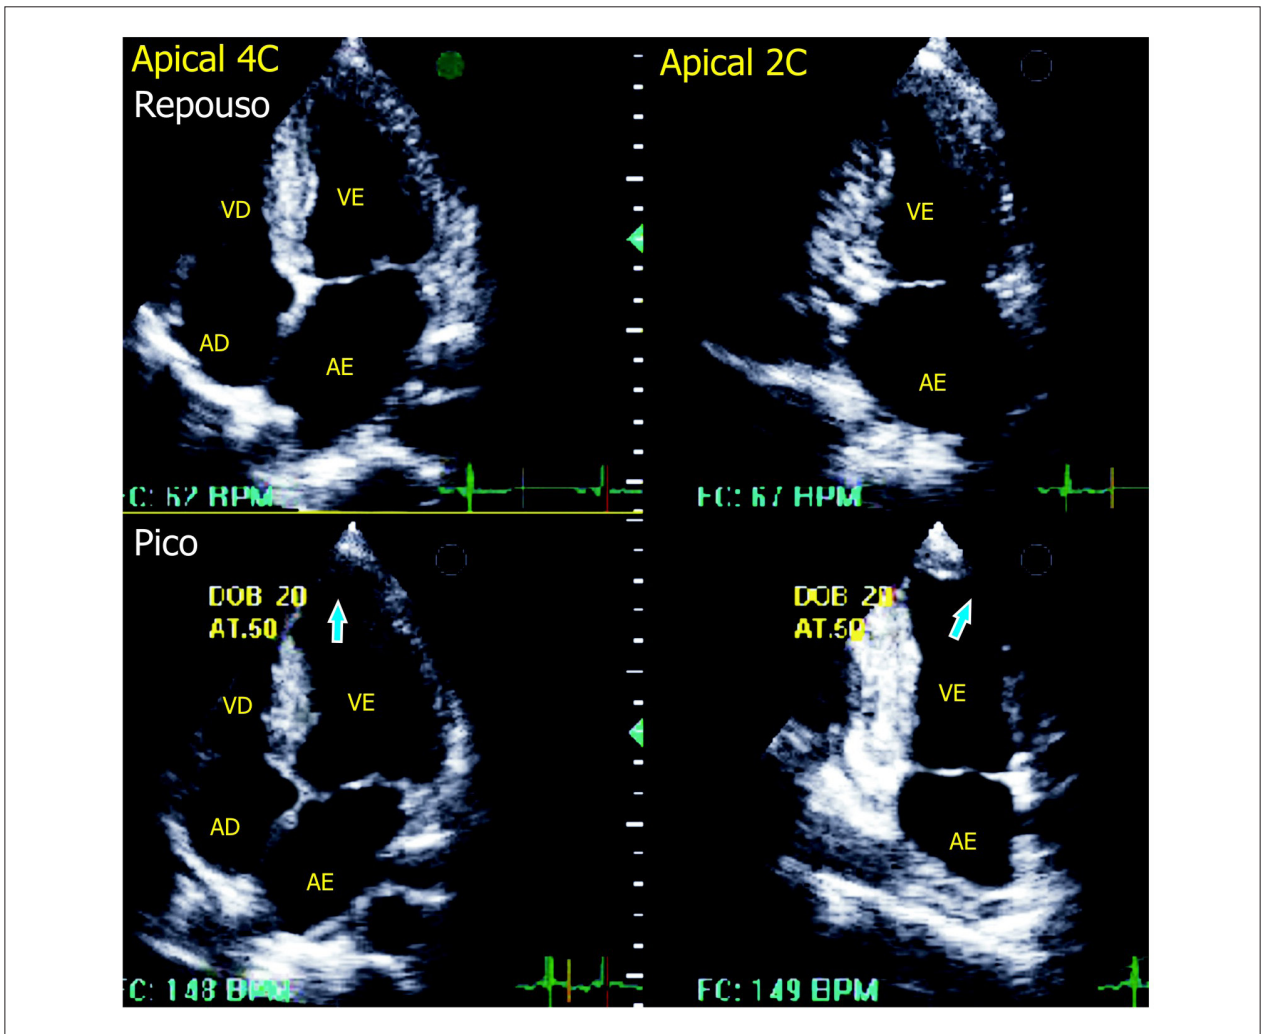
Stress echocardiography: contractile deterioration in apical region and anterior wall at peak test (arrows), apical cuts of 4 and 2 chambers. RA = right atrium, LA = left atrium, RV = right ventricle, LV = left ventricle.
